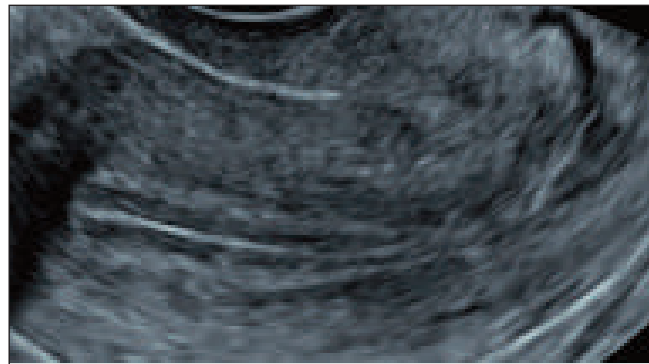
measuring endometrial thickness on 2D ultrasound
